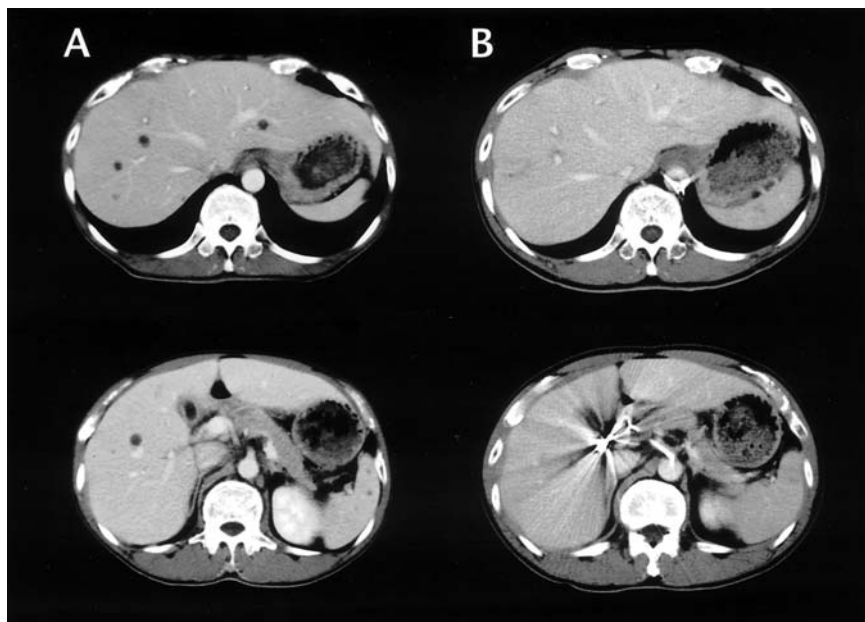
Enhanced computed tomography. A Before antifungal therapy, numerous small low-density areas were seen in the liver and spleen. B After a few months of treatment with intraarterial infusions of amphotericin-B, the low-density areas had disappeared
